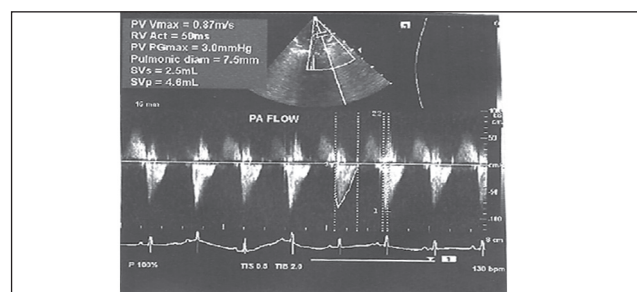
Pulsed Doppler evaluation of pulmonary artery flow.
